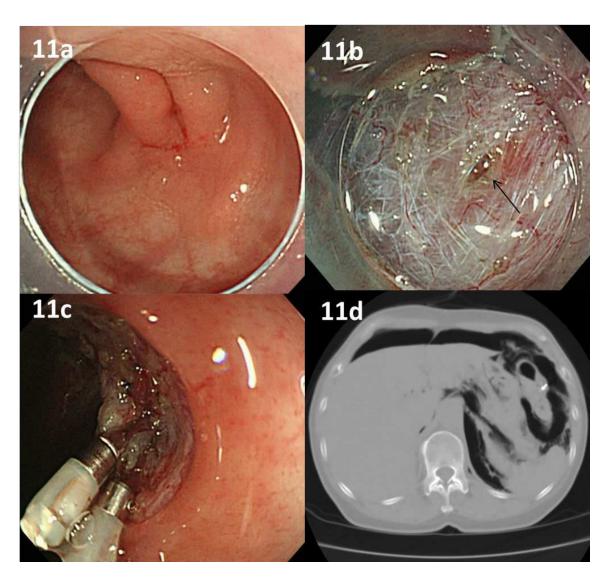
Perforation during ESD. 11a: 0–lla 30 mm on the descending colon. 11b. Coagulation to submucosa during resection of submocosa below the tumor caused perforation (black arrow). 11c: The hole was closed by endoscopic clipping. 11d: CT revealed free air out side of the colorectum.
